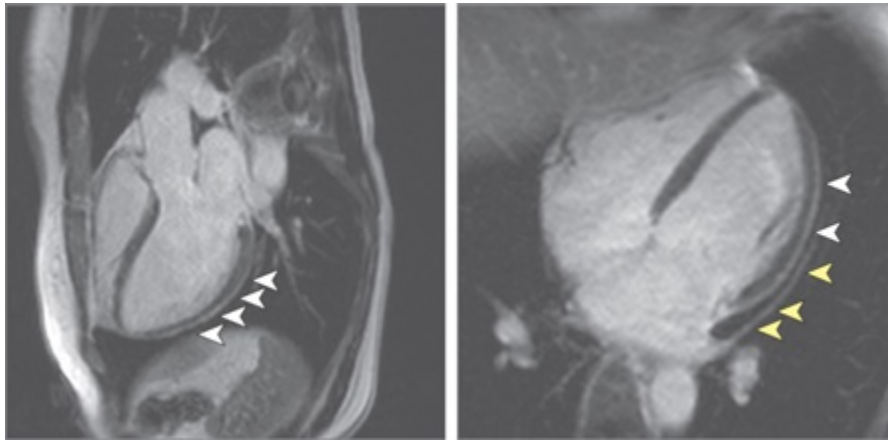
Cardiac MRI of an elderly patient with elevated high-sensitivity troponin T level. Pericardial effusion and enhancement (arrowheads) and epicardial and intramyocardial enhancement (arrowheads) are remarkable (Adapted from Puntmann, 2020).
